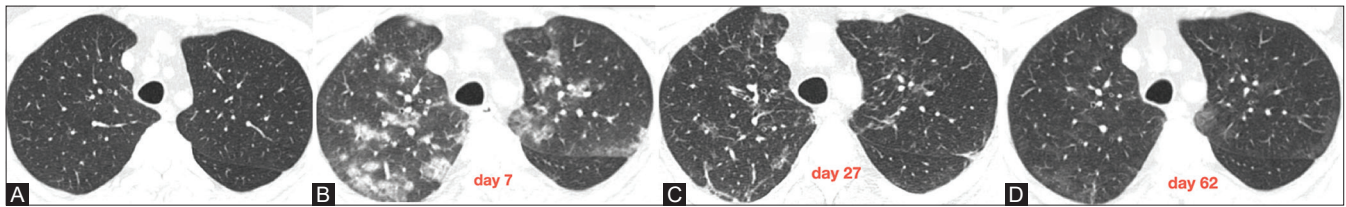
(A-D): HRCT (A) early in disease reveals no abnormality. HRCT (B) 7 days after first scan reveals peribronchovascular ill-defined consolidations. HRCT (C) 27 days after first scan demonstrate resolution of the consolidations. HRCT (D) 62 days after first scan shows near total resolution
